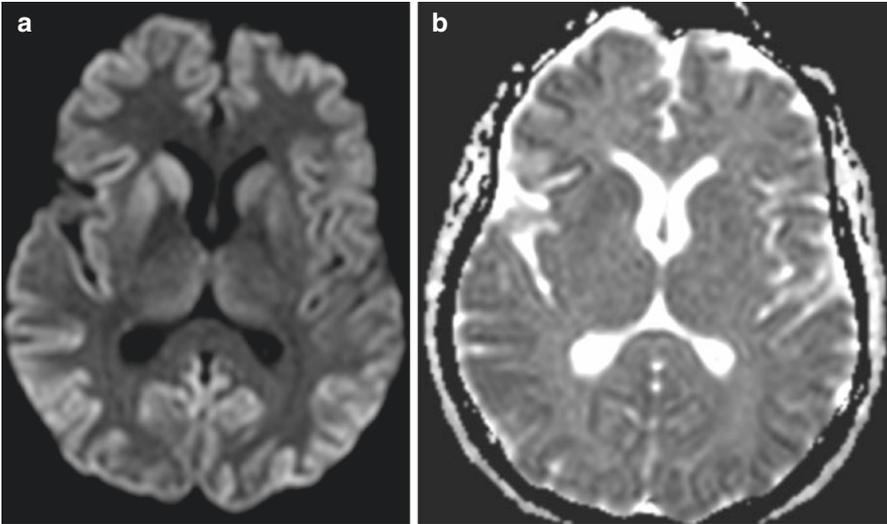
(a) Brain diffusion weighted magnetic resonance imaging shows hyperintensities of the caudate heads and putamina greater on the right as well as hyperintensities of the right insular cortex and bilateral parietal, occipital, and posterior cingulate cortices. (b) Brain apparent diffusion coefficient (ADC) magnetic resonance imaging shows cortical hypointensity in many cortical regions that is most prominent in the right frontal cortex. In prion disease, cortical ADC hypointensity is more subtle and rare than caudate, putamen, and thalamic hypointensity
